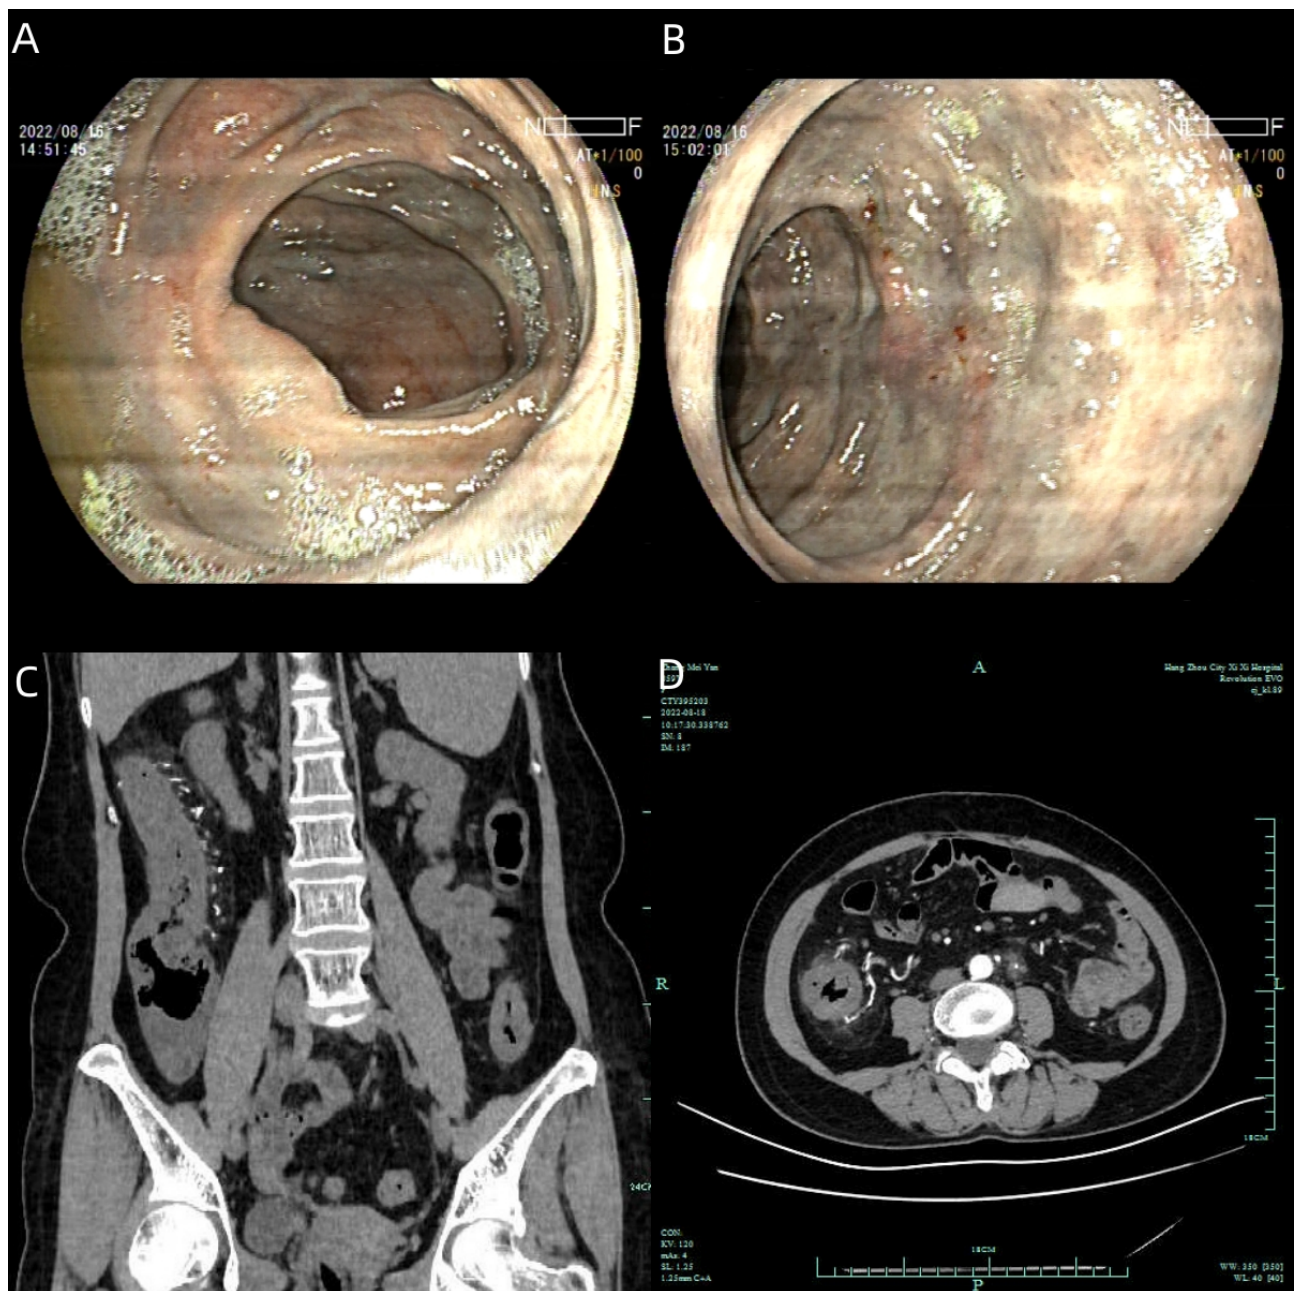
A and B. Colonoscopy shows that the colonic mucosae is dark purple, the lumen is narrow, the semilunar folds are significantly thickened, the vascular markings disappear and redness and erosion of local mucosa are observed. C and D. Computed tomography (CT) shows extensive lesions in the ascending and transverse colon, thickened intestinal wall and extensive calcification of mesenteric vessels in corresponding areas.
